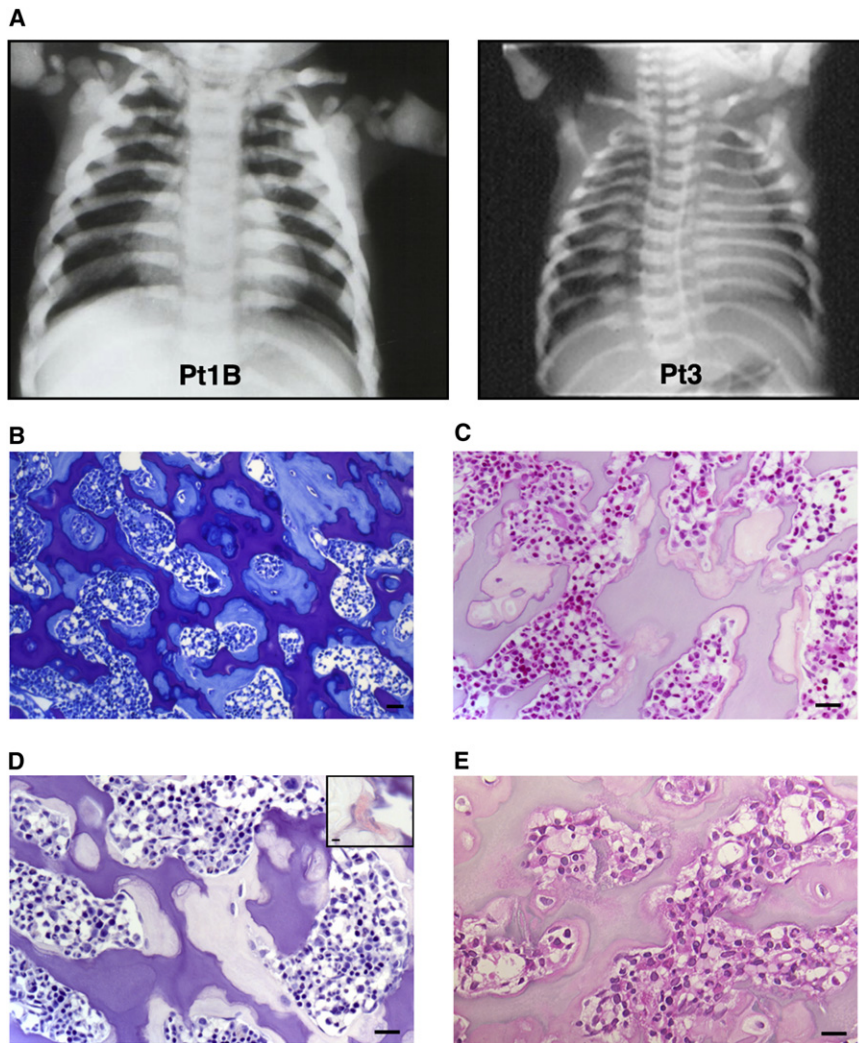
Chest X-Rays and Bone Biopsies of Some Patients
